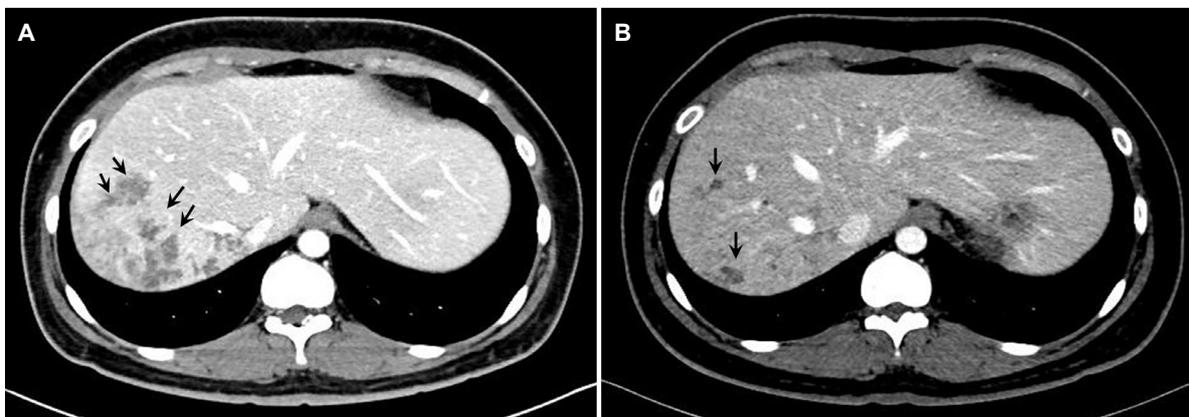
Axial computed tomography scan images of the case one patient. (A) Multiple clustered hypodense lesions (black arrows) were observed (on the admission day). (B) Few hypodense lesions (black arrows) were observed (Four months from discharge).
